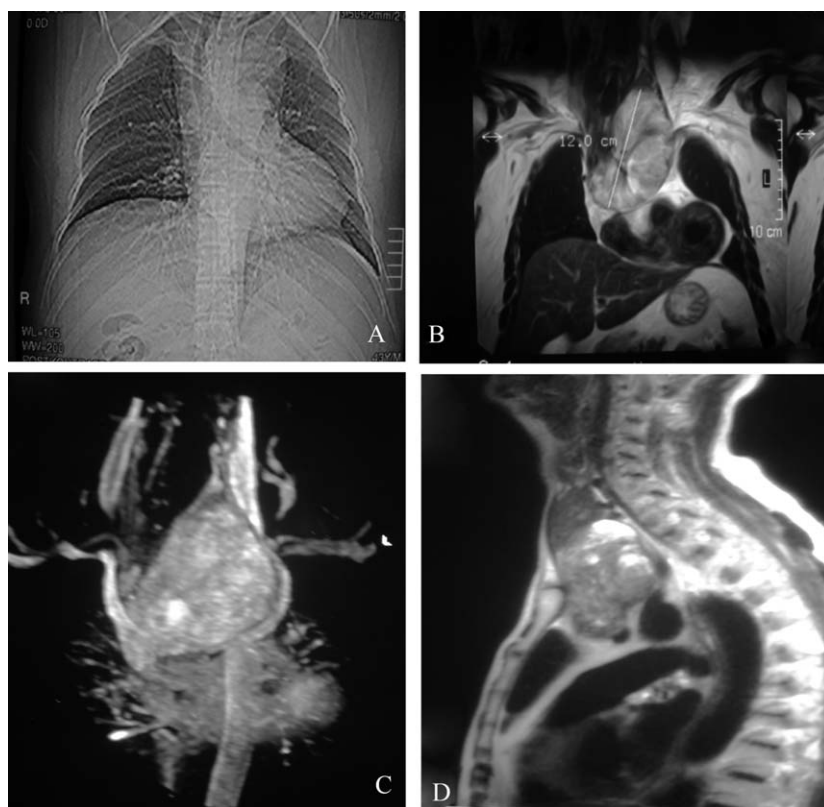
(A) Coronal CT scan showing substernal goiter exerting significant tracheal deviation. (B) Coronal plain MRI scan showing substernal goiter. (C) MR angiography showing major vessels displacement by a substernal goiter. (D) Sagittal plain MRI scan showing substernal goiter.
